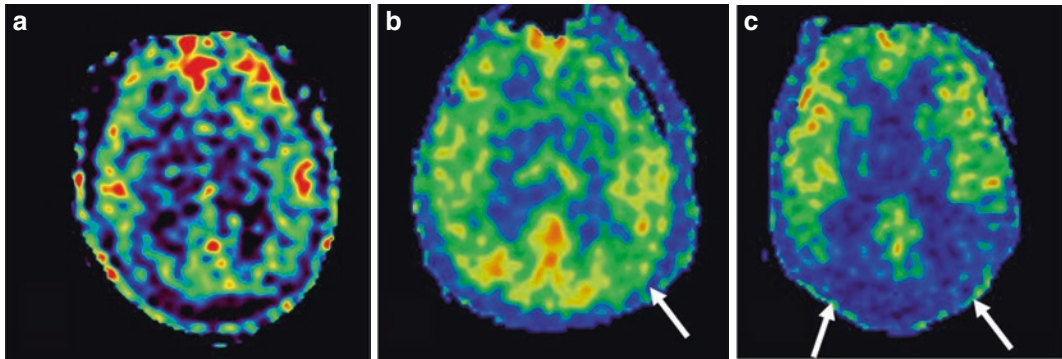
CBF images of healthy elderly subjects, and patients with MCI and AD: A healthy 67-year-old female, MMSE 29, CDR 0, transverse T1WI MRI shows no abnormal brain structures, and ASL shows no CBF decrease (a), a 70-year-old male patient with MCI, MMSE 23, CDR 0.5; transverse T1WI MRI shows no abnormal
